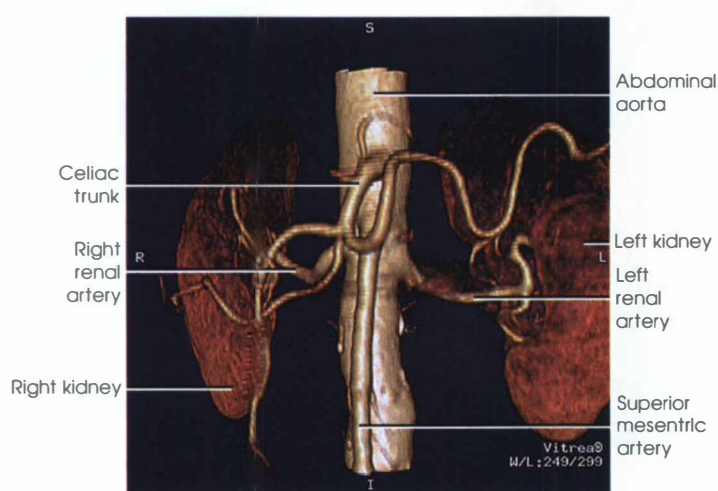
Color CT angiography of the renal vessels in 3D format.
